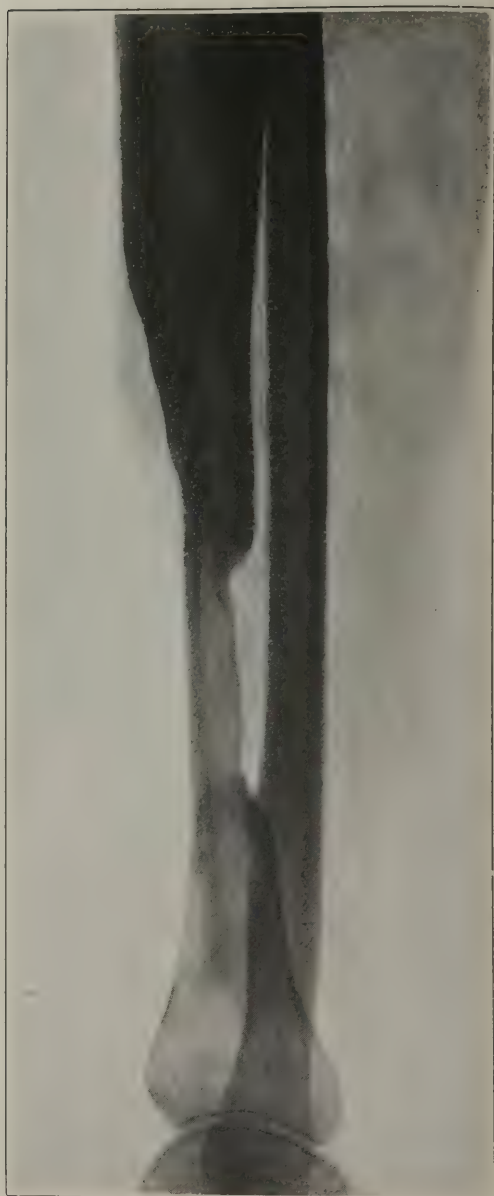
Case 12. Roentgenogram three months after graft
